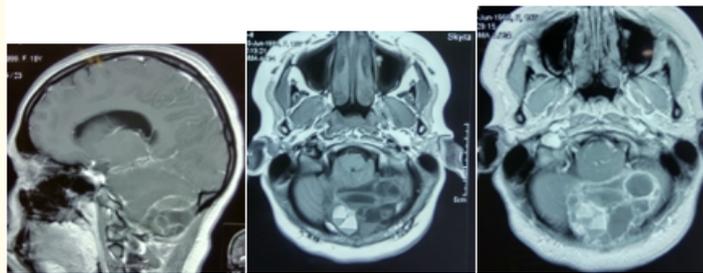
Showing MRI with contrast image having multiple soap bubble within lesion. The main mass of lesion lies with posterior fossa.
